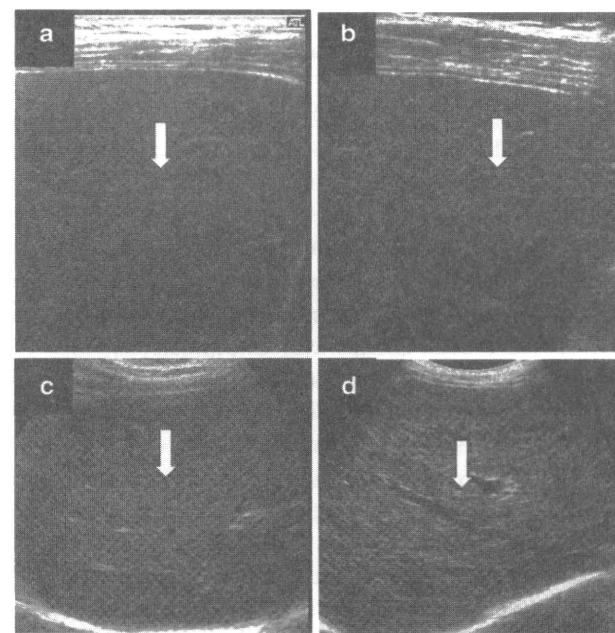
Scores for the ultrasonographic features of the liver parenchymal texture; a fine parenchymal texture with a high-frequency probe, b a mildly coarse parenchymal texture with a high-frequency probe, c a coarse parenchymal texture with a low-frequency probe, and d a highly coarse parenchymal texture with a low-frequency probe
